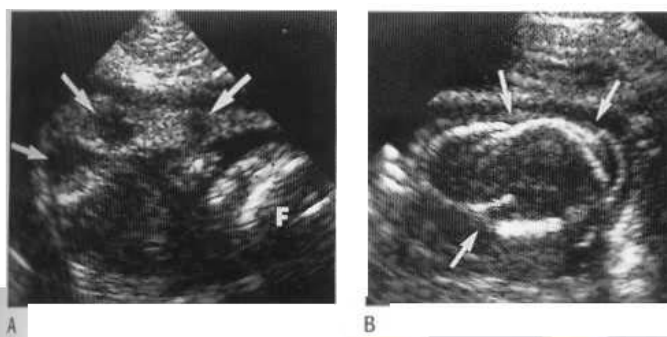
(A) Multiple hypoechoic placental infarcts (arrows) in a patient with a systemic vasculitis. F = fetus. (B) Sonographic Spalding's sign following fetal death; same patient as in (A).
